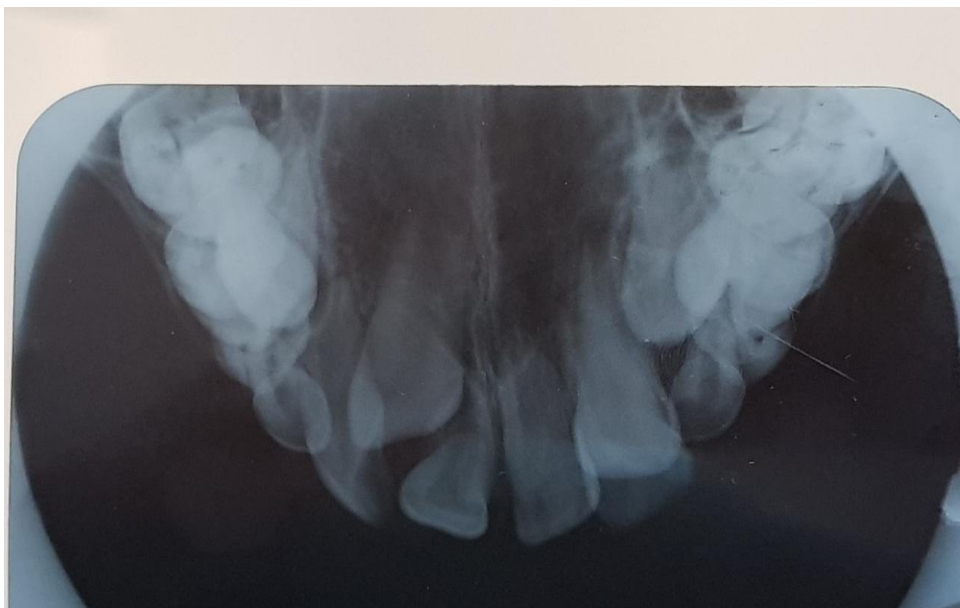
Intraoral occlusal radiograph
